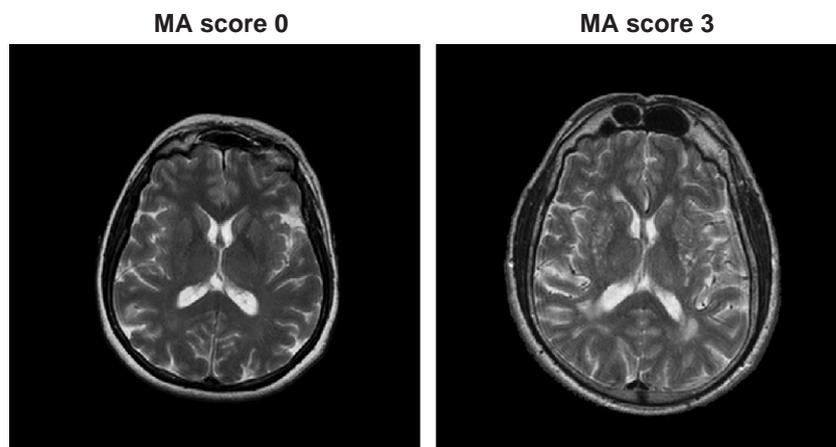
T2-weighted MR scans of two participants, classified as low (score: 0, left) or high (score: 3 right) on the microangiopathy scale. While there were no small vessel abnormalities in the participant with score 0, the participant with score 3 shows hyperintensity in the periventricular white matter and in subcortical regions. For details, see Methods section.
